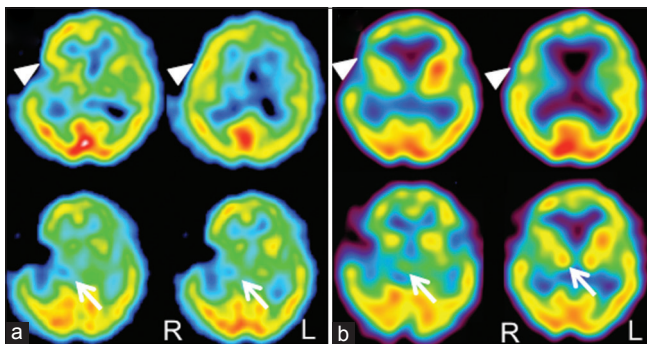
(a) ^{99m}Tc -ECD SPECT performed 3 days after surgery revealing hyperperfusion in the frontal cortex (arrowheads). There was also slight hypoperfusion in the right basal ganglia including the subthalamic nucleus (arrows). (b) ^{99m}Tc -ECD SPECT obtained 8 weeks after surgery showed the resolution of hyperperfusion in the right frontal cortex (arrowheads) with the resolved laterality of the perfusion in the subthalamic regions (arrows)
